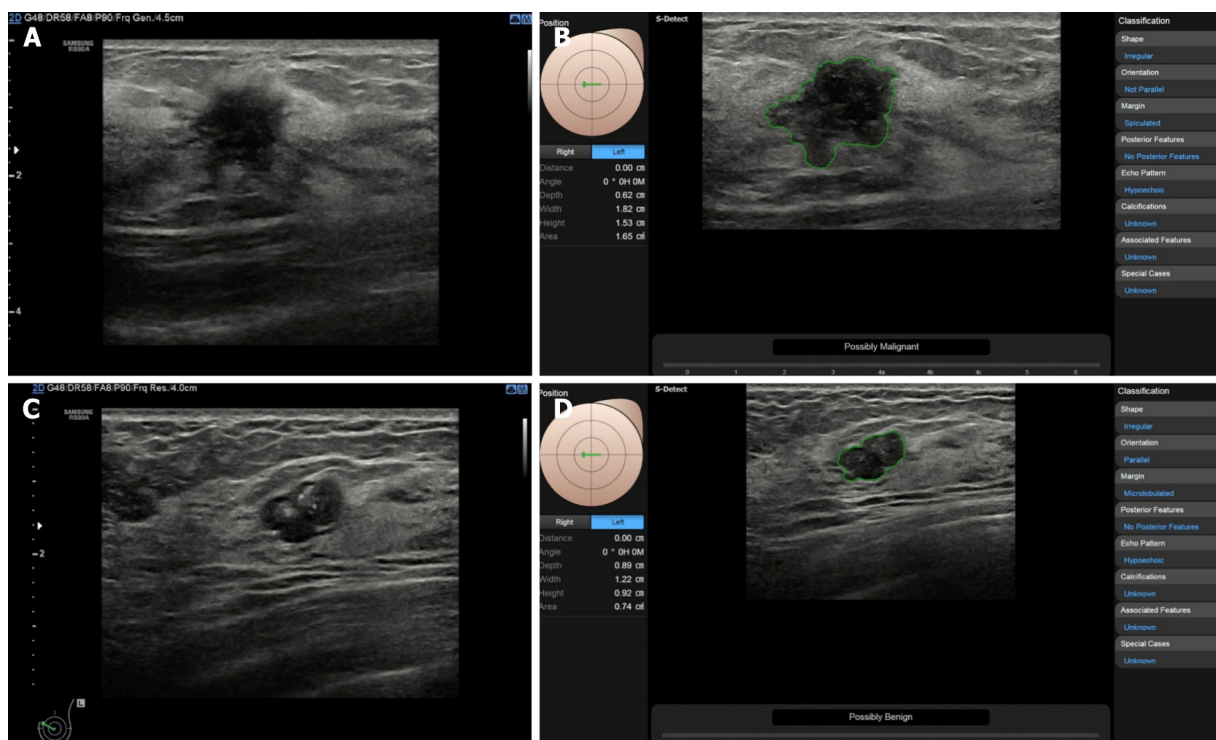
S-detect technique in the Samsung RS80A ultrasound system. A and B: In a 47-year-old woman with left invasive breast cancer on B-mode ultrasound (A), S-detect correctly concluded that it is "Possibly Malignant" based on the lesion features listed on the right column (B); C and D: In a 55-year-old woman with fibroadenoma of left breast on B-mode ultrasound (C), S-detect correctly concluded that it is "Possibly Benign" based on the lesion features listed on the right column (D).
